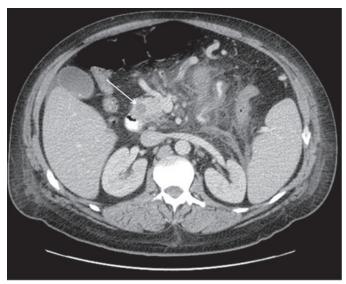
Computed tomography scan of abdomen/pelvis that visualizes the non-specific pancreatic mass (arrow) located in the head of the pancreas.
